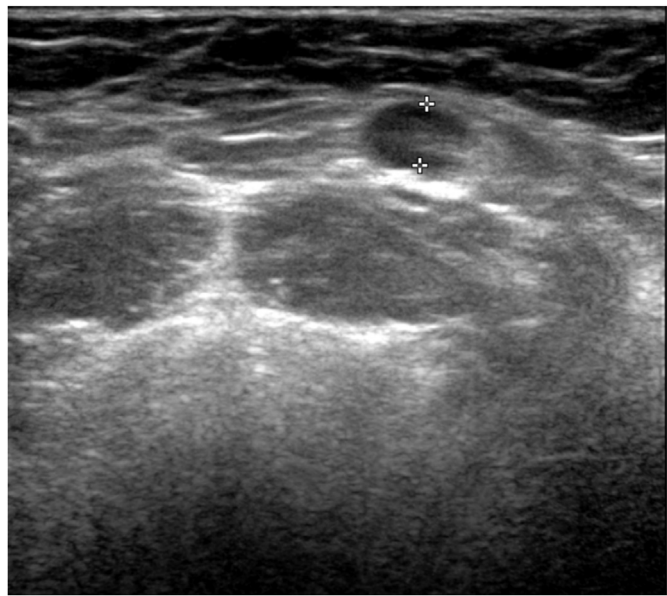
The ultrasound scan of the left parotid revealed a lobulated slightly ill defined hypoechoic mass measuring $2.3 \times 1 \times 1.6$ cm.
